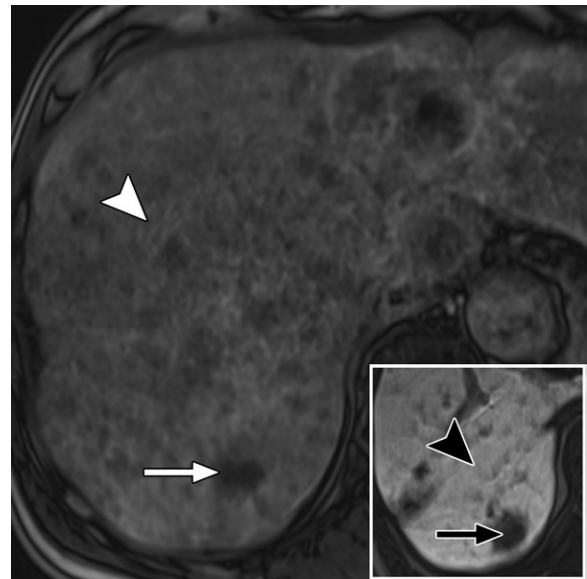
Axial MR images show the effects of liver dysfunction on background liver hyperintensity with gadoxetate-enhanced HBP imaging in a 69-year-old man with metastatic melanoma. In the setting of liver dysfunction and a serum total bilirubin level of 3.1 mg/dL, background liver signal intensity is diminished (white arrowhead) compared with normal liver signal intensity (black arrowhead) on an image from a prior examination (inset) when the bilirubin level was 1.2 mg/dL. A segment VII metastasis (black and white arrows) is depicted on both images, but with less contrast than the background liver with progressive liver dysfunction.
